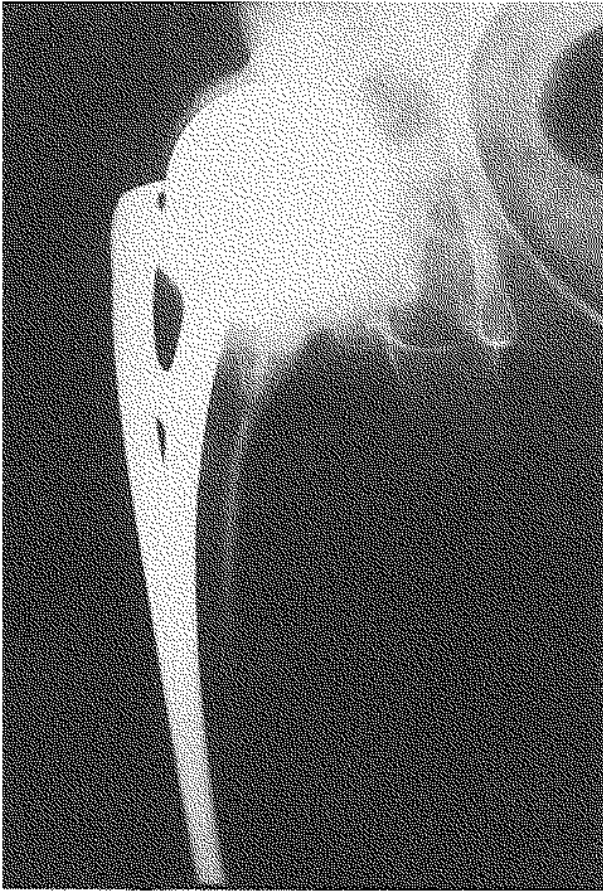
AP roentgenogram of the right hip showing severe acetabular erosion related to an uncemented Austin Moore hemiarthroplasty performed 15 years before. A revision hip arthroplasty was then indicated.
